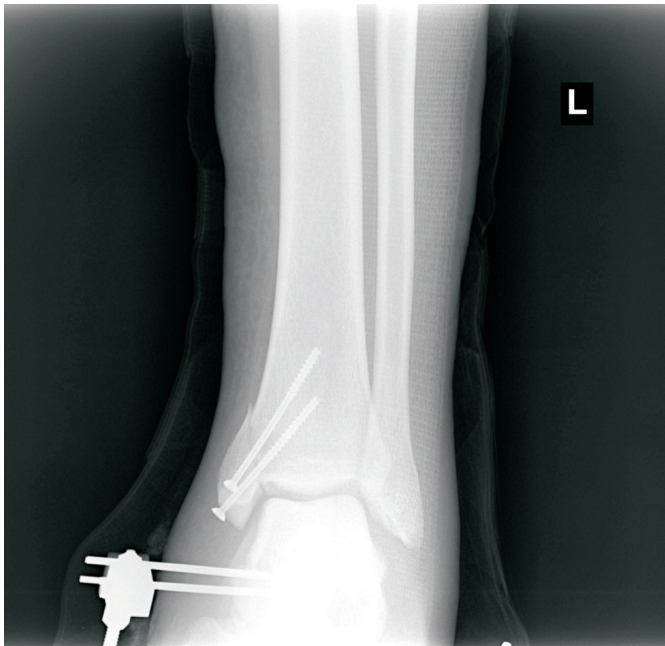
Radiographic view of the ankle at 2 weeks postoperative.
